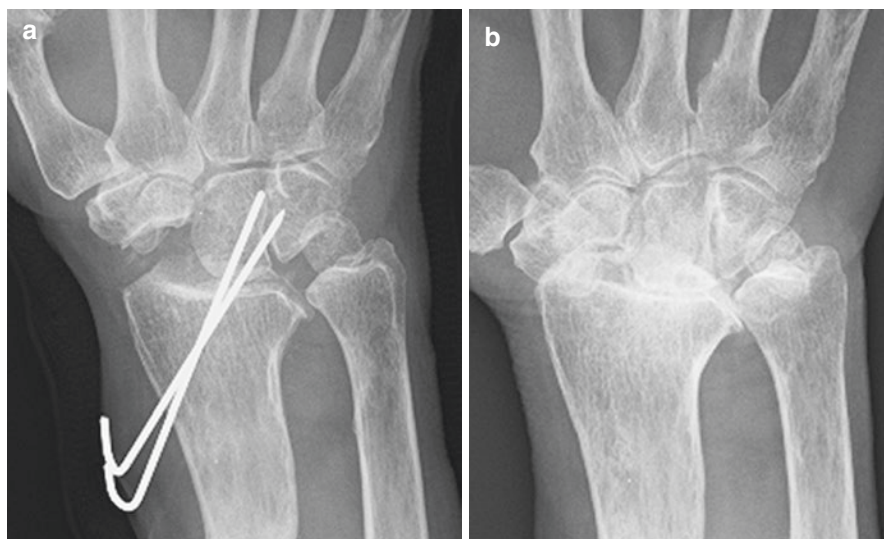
(a) Immediately after performing PRC. (b) 8 years postoperatively. At 8 years after performing PRC, an X-ray shows the development of radiocapitate arthrosis
